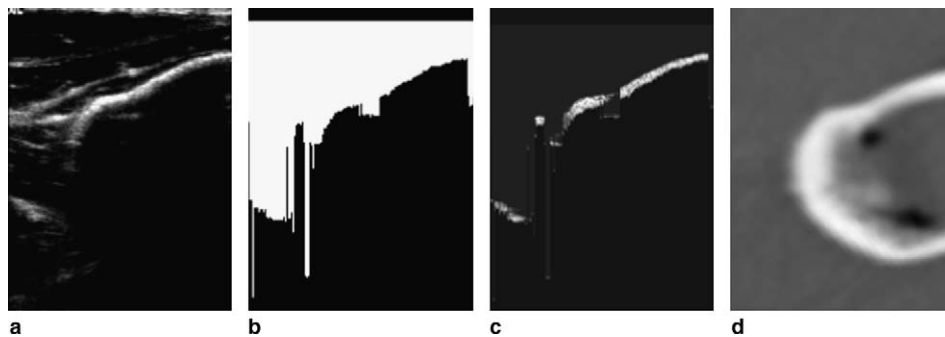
Overview of the formation of the US probability images: (a) a sample US slice through the femur; (b) the mask produced by the artifact removal stage (only pixels in the white region are included for subsequent image processing and registration); (c) the final probability image; (d) the corresponding reformatted slice through the CT volume (calculated using the “gold standard” transformation) to show the position of bone boundaries. In (c) some non-bone-boundary pixels can be seen to have been allocated a high value in the probability image and vice-versa. However, we would like to reiterate that our aim is not to produce a perfect segmentation, but to produce probability images of sufficient quality to allow accurate and robust registration.
